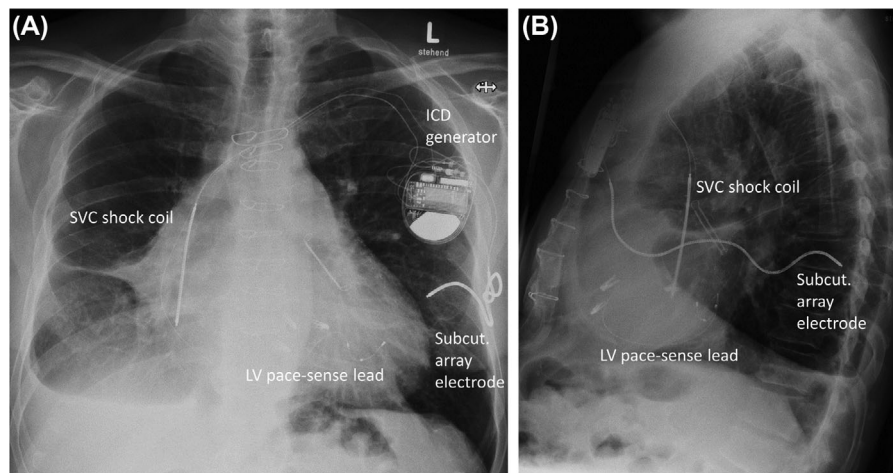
Chest radiograph (A, posterior-anterior radiograph, B, lateral radiograph) of the off-label lead/device setup, which was implanted after explantation of the subcutaneous ICD. A pace-sense lead was placed in a posterolateral vein, a superior vena cava (SVC) coil was placed partially in the superior vena cava and partially in the right atrium, and a subcutaneous array electrode was implanted in the subcutaneous tissue of the left lateral chest wall. Abbreviations: ICD, implantable cardioverter-defibrillator; LV, left ventricular; Subcut., subcutaneous
